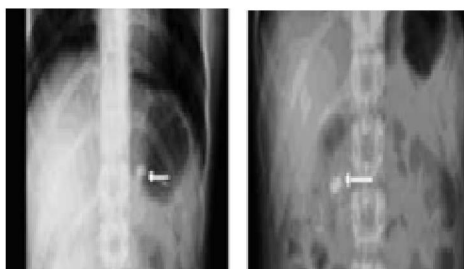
Radiographic photo images showing the presence of a BaSO<sub>4</sub>-loaded floating tablet (F9) in the stomach at different time periods. The tablet altered its position in the stomach.
